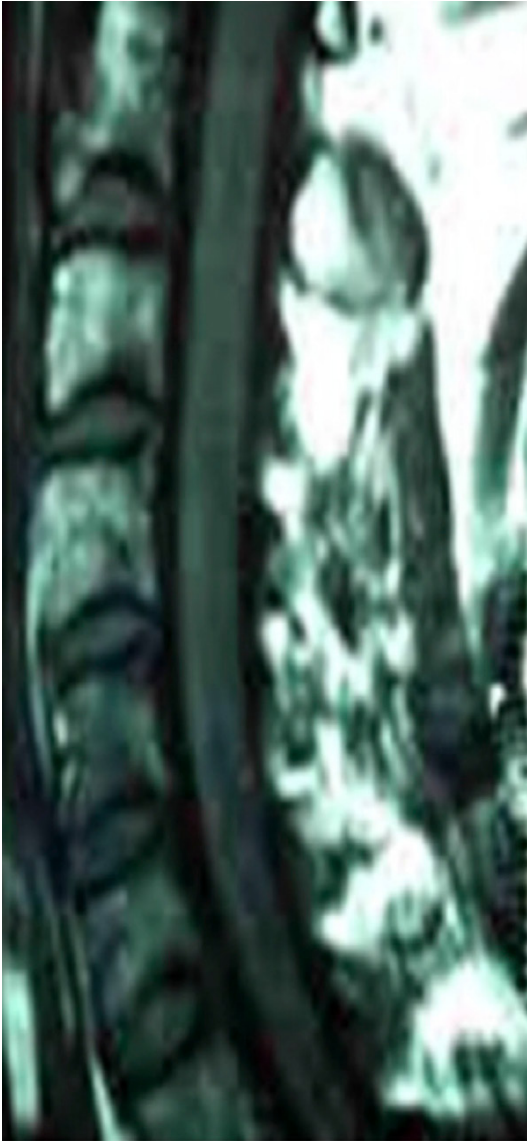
Preoperative MRI scan of a 51-year-old man with pain neck and shoulder, showing severe cervical degenerative changes. Ten months before the onset of ALS, he was operated by cervical spondylosis.
